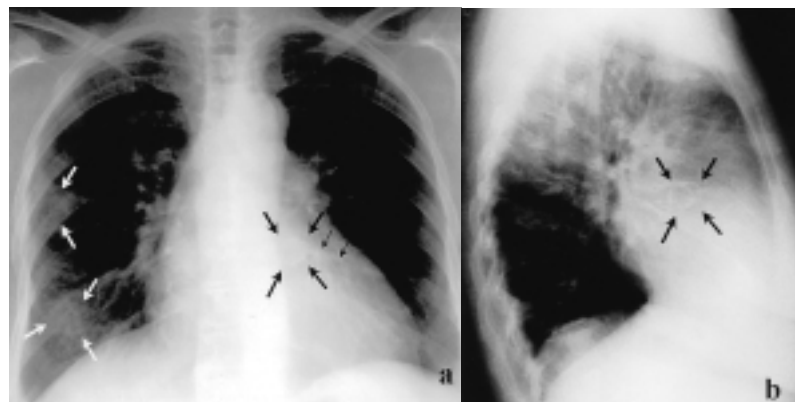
Chest X-rays show coronary calcifications (black arrows) and signs of localized pulmonary fibrosis (white arrows) in an antero-posterior view (a). Calcification of the left main coronary aneurysm (arrows) as seen at chest X-rays (lateral view) (b).
